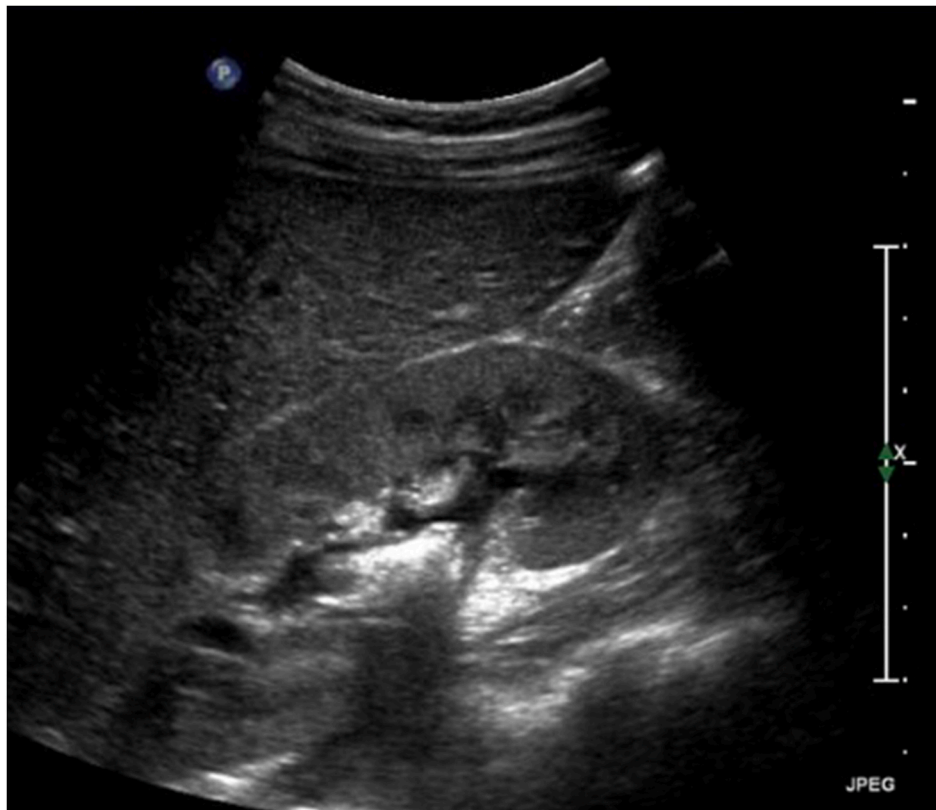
Preoperative longitudinal ultrasound of right kidney demonstrating shadowing debris in renal pelvis.
